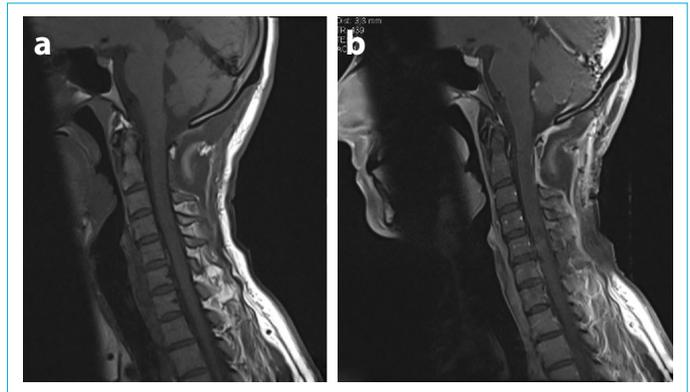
(a, b). (a) Sagittal T1 and contrast-enhanced T1 weighted, (b) magnetic resonance imaging confirmed a total resection.
